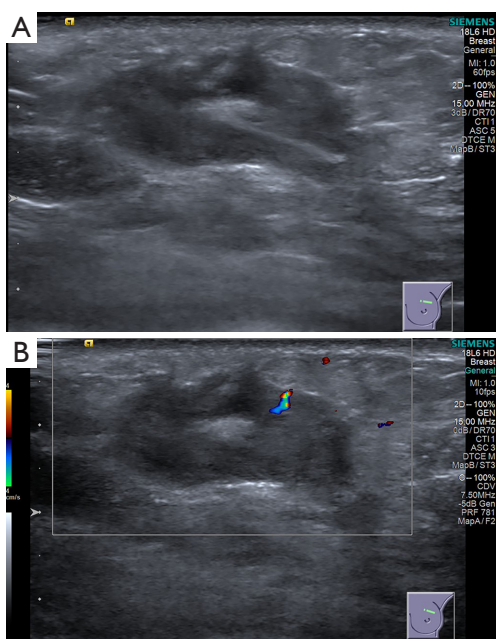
Two-dimensional and color Doppler ultrasound images of mass. (A) Left breast features a hypoechoic mass approximately 30 mm × 13 mm × 20 mm in size at the 12 o'clock position, with unclear borders and irregular shape. The internal echogenicity of the mass is heterogeneous, with only slight hypoechogenicity visible. (B) Color Doppler ultrasound displays a prominent thick vessel within the tumor.
